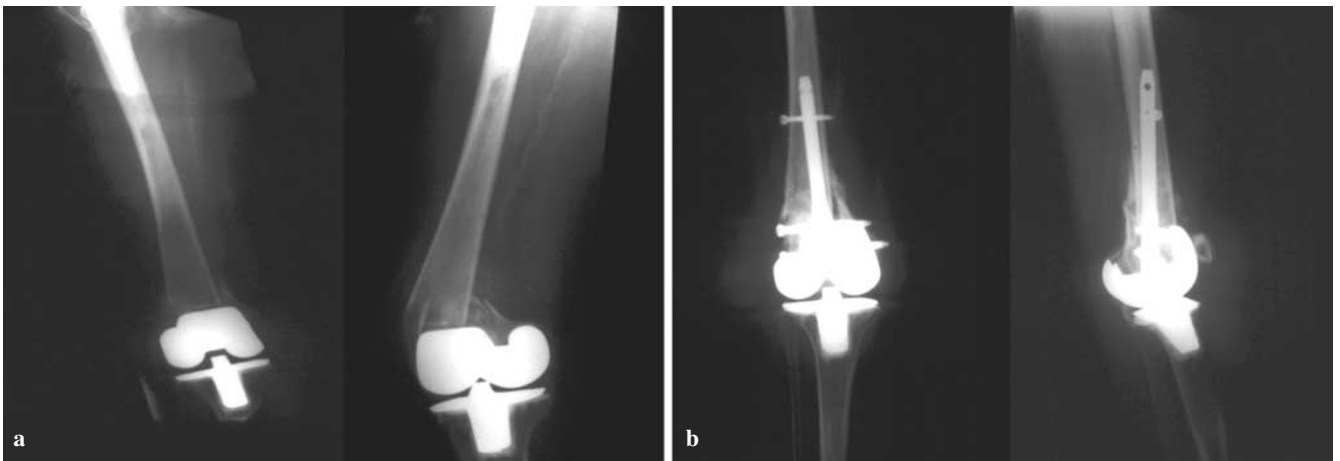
Periprosthetic fracture of the distal femur above knee arthroplasty in 42-year-old woman with rheumatoid arthritis. a Pretreatment radiograph. b Radiograph of the knee three months after nailing showing satisfactory fracture healing
